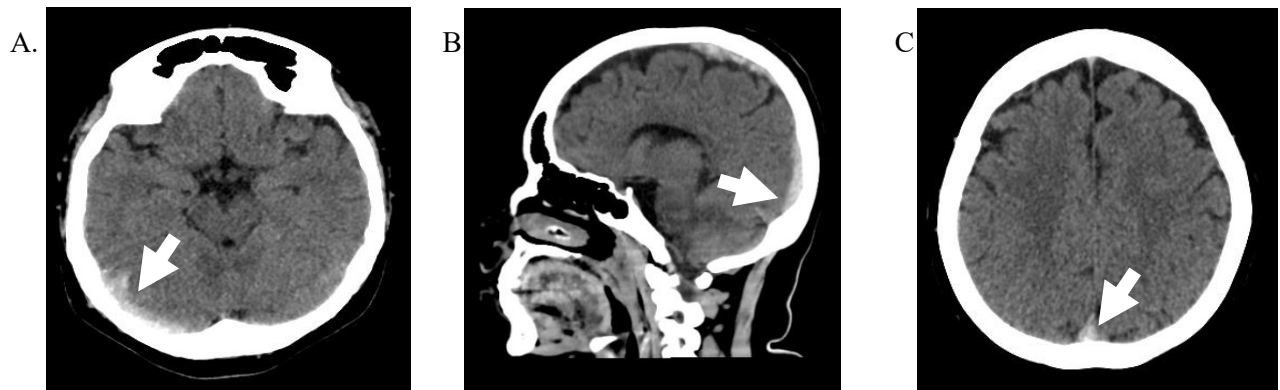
Non-Contrast Head CT scan
